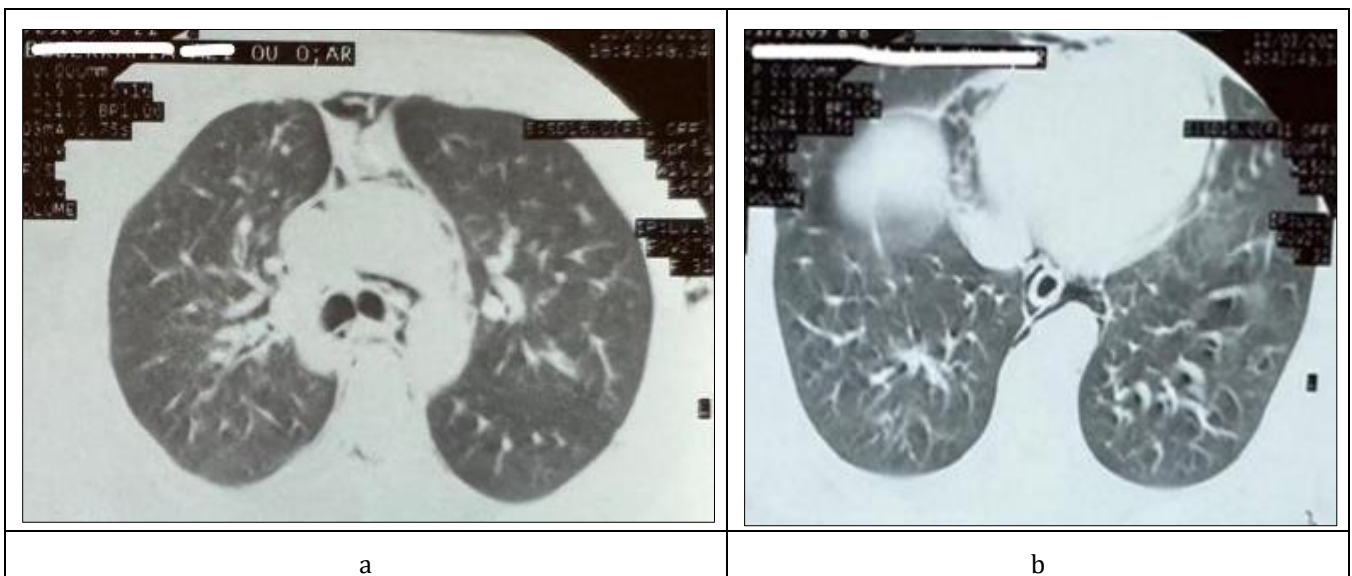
a and b: thoracic CT scan showing mediastinal air
